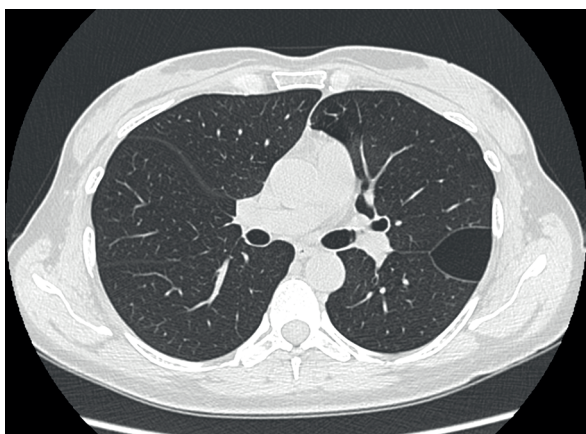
A control CT exam at day 40 after Covid-19 infection of a 57-y.o. woman shows a persistent, singular, interlobular lung cavity.
